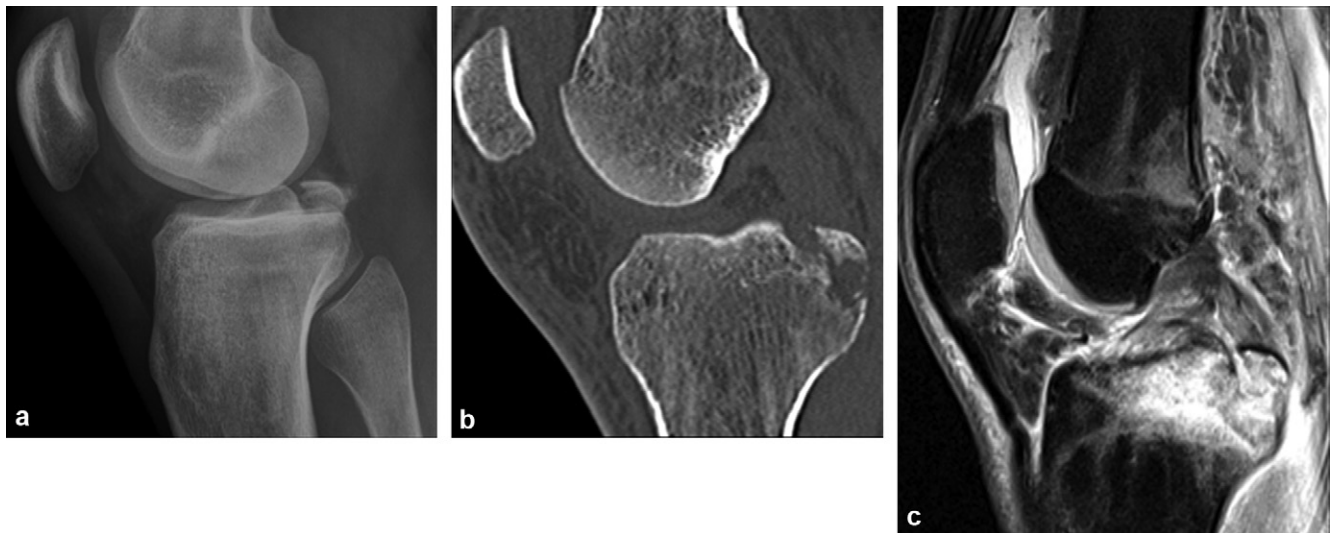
Avulsion of the PCL at its insertion on the posterior intercondylar area. a: standard X-ray; b: sagittal CT; c: fat-suppressed T2 weighted MR.
